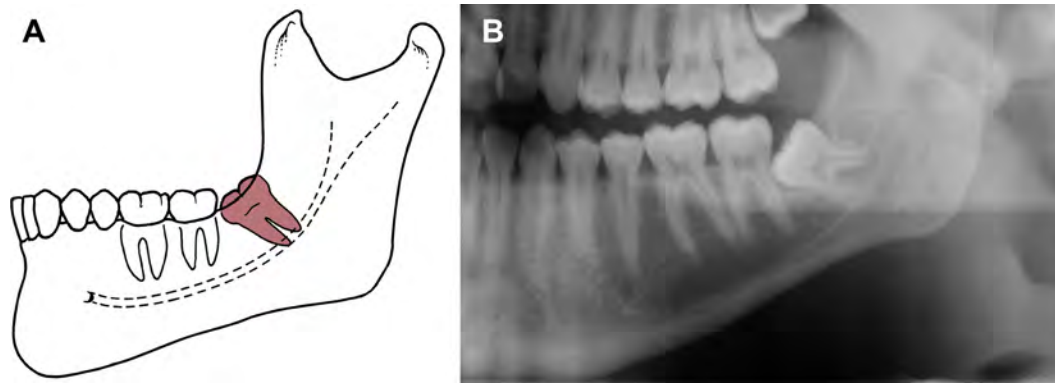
Classification of impacted third molars according to angulation. This classification describes the angulation of the long axis of the impacted third molar with respect to the long axis of the second molar. (A) Mesioangular mandibular impaction—most common and easier impaction to remove. (B) Radiograph of mesioangular impacted mandibular third molar. ([A] Adapted from Hupp JR, Ellis E III, Tucker MR, editors. Contemporary oral and maxillofacial surgery. 5th edition. St. Louis: Mosby Elsevier; 2008; with permission. Modified by Ion Syrbu.)
